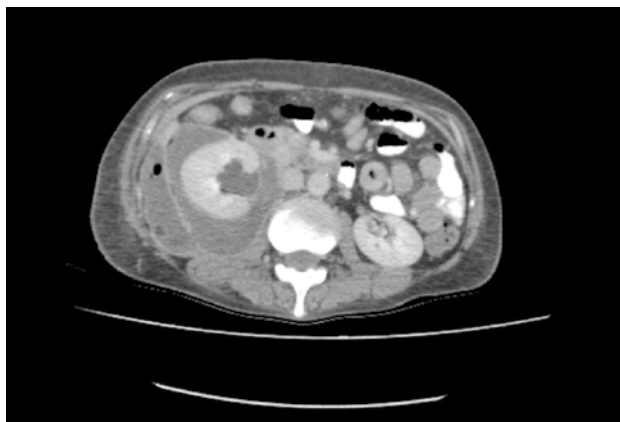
Axial contrast-enhanced CT image demonstrating a retroperitoneal fluid collection with internal gas, consistent with abscess formation.
